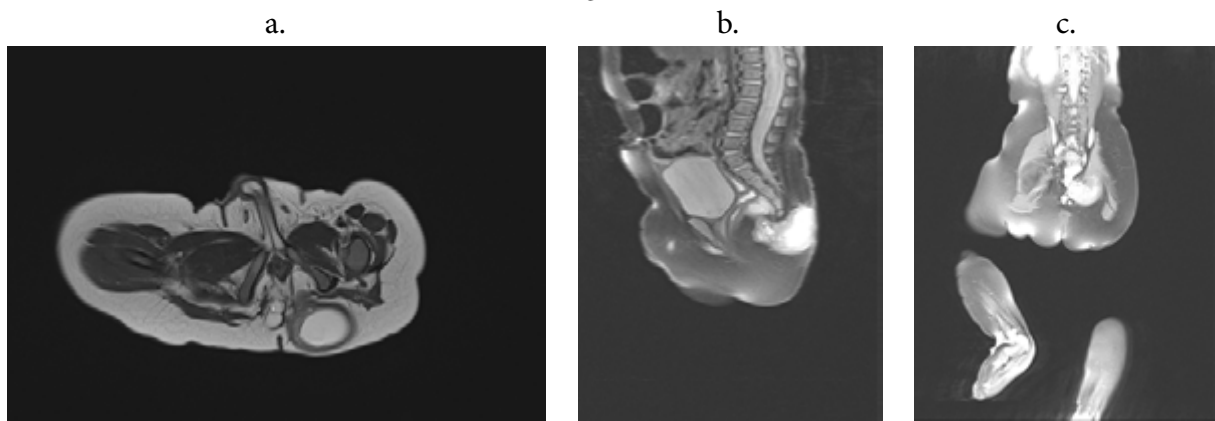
MRI T2 weighted images (axial, coronal and sagittal planes) showing a sacrococcygeal lobulated heterogeneously enhancing mass measuring 50x38mm. T2 axial plane (a) demonstrating the dominantly extrapelvic and small intrapelvic localization of the SCT. T2 coronal plane (b) confirming the predominant extrapelvic localization of the SCT. T2 sagittal plane (c) identifying the small intrapelvic component of the SCT.
